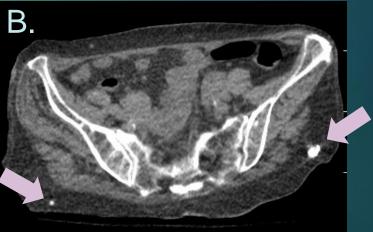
Unenhanced CT images demonstrate several calcified nodules in the buttock subcutaneous tissues. These were in keeping with calcified injection granulomas.
